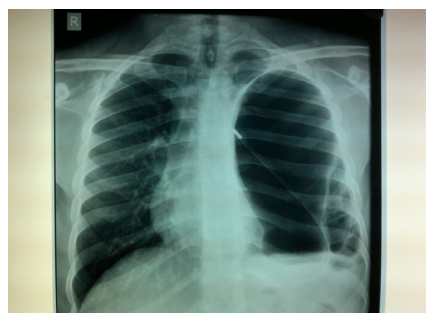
Chest radiography revealing absent lung marking on left side, right sided mediastinal shift, nasogastric tube coiling back to left hemithorax, and blunting of left dome of diaphragm.
